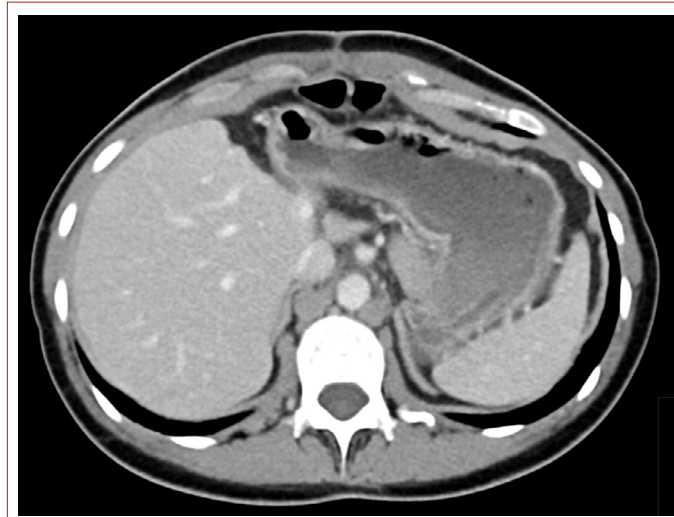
The post-operative CT scan at the 3-month follow-up.
